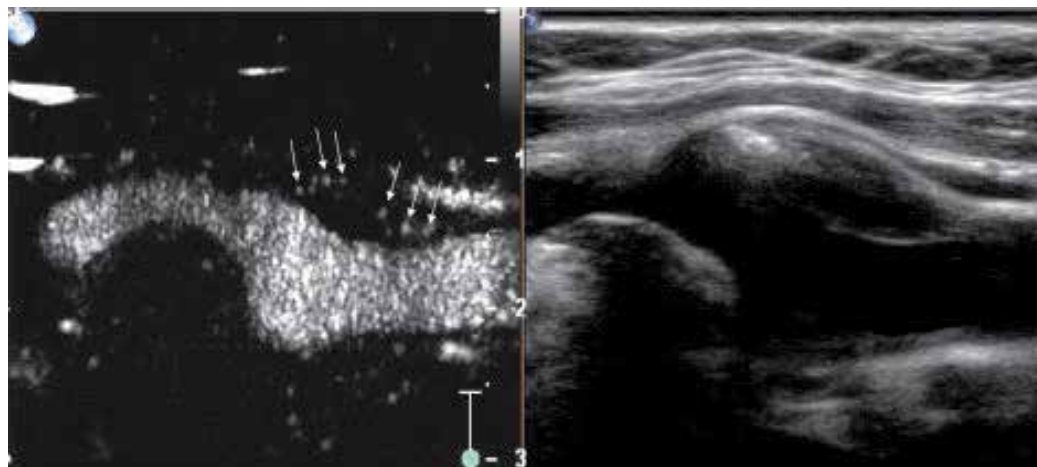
Left: Contrast-enhanced ultrasound showing neovascularization in carotid artery plaque. Microbubbles within the plaque are indicated by arrows. Right: Corresponding B-mode ultrasound image without contrast. *In Staub et al. (2010b), used with permission.*
